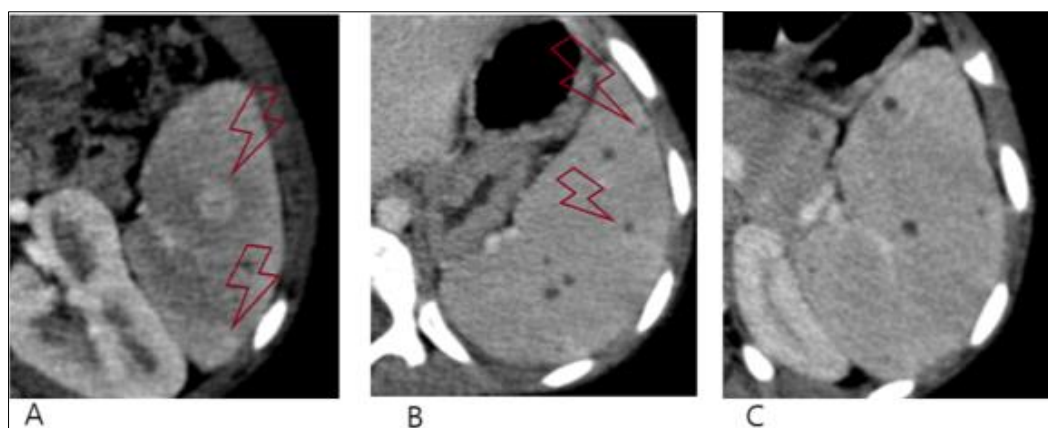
splenic involvement on CT scan after contrast injection:
